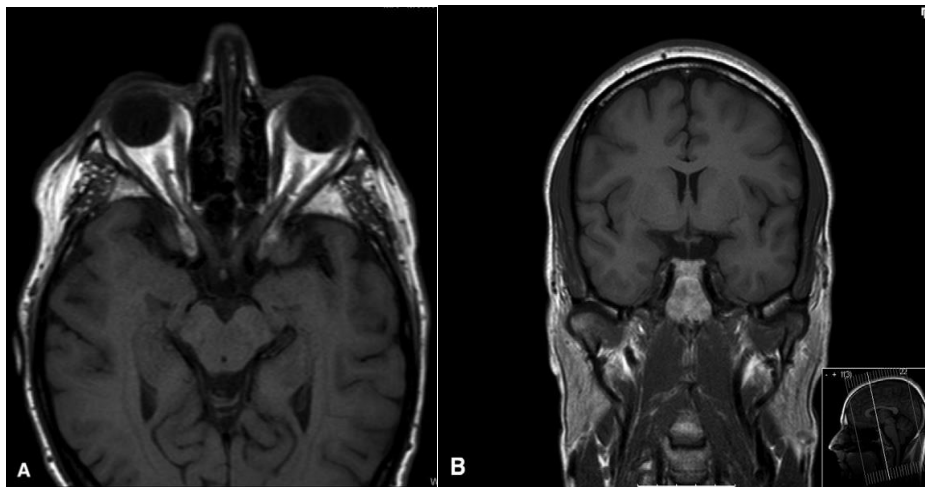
T1 weighted axial& coronal MRI showing the position and immediate relationship of the chiasm to adjacent anatomical structures. (Bergland et al., 1968).
